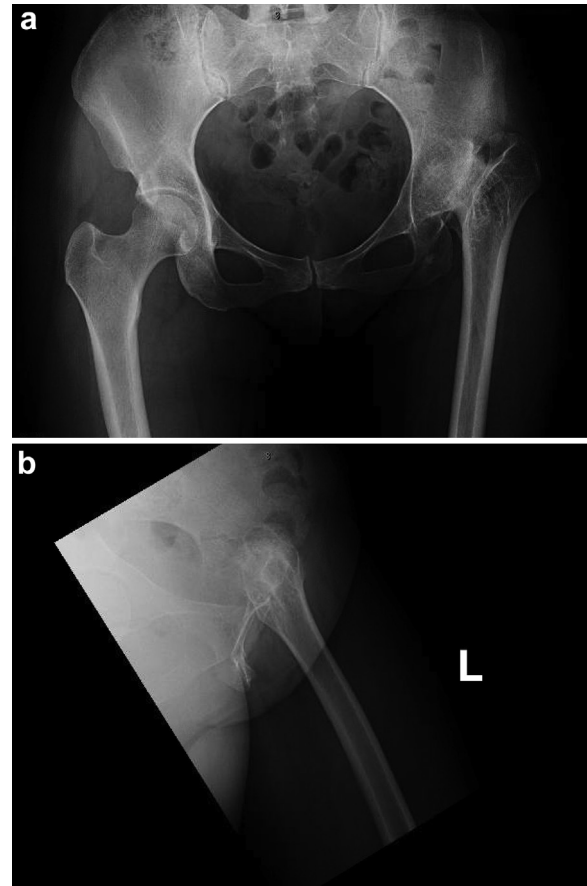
(a and b) Case 1: Preoperative anteroposterior (AP) pelvis and frog-leg lateral radiographs.
